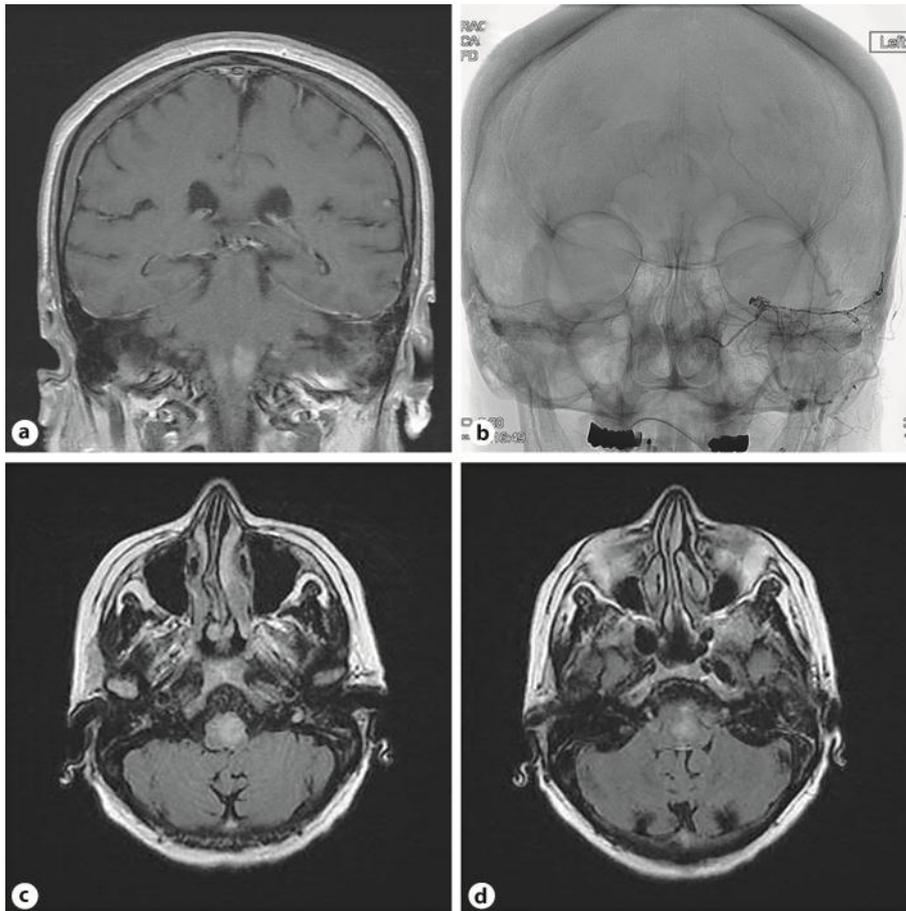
Status following Onyx embolization. a MRI coronal post-gadolinium T1 image showing medullary edema. b Left tentorial apex dAVF as visualized in anteroposterior plane, un-subtracted, demonstrating the Onyx embolization at the petrous apex. c, d Axial flair sequences showing medullary edema.
